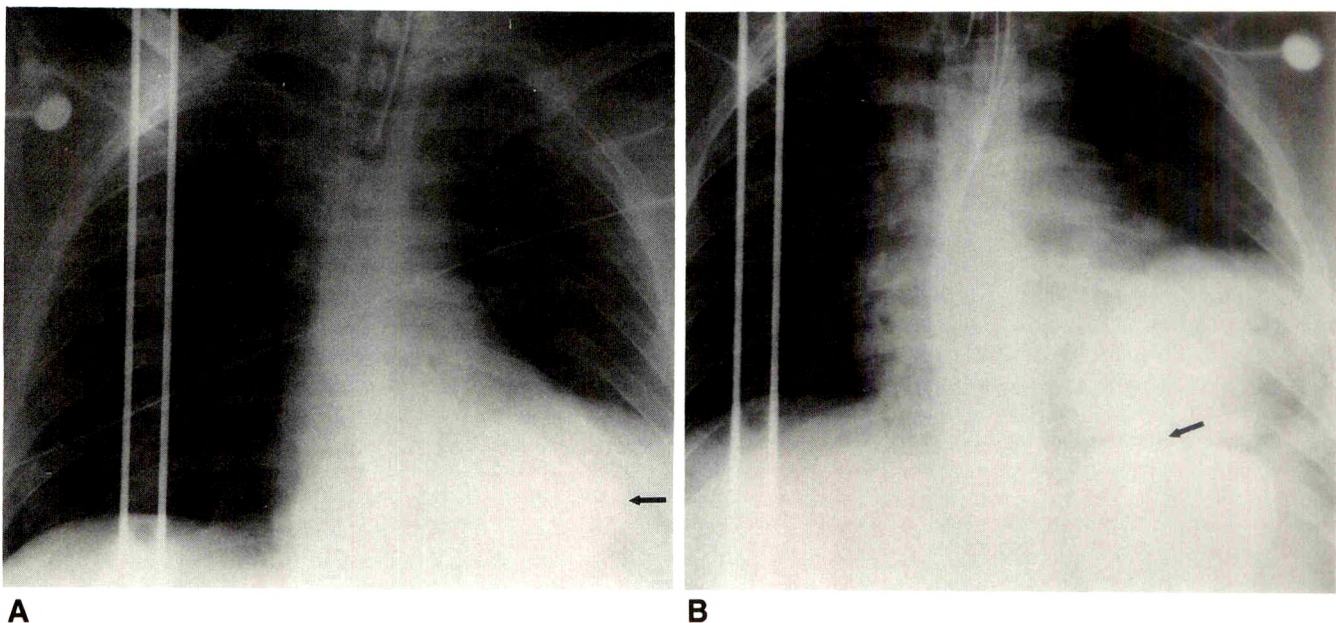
A, Chest radiograph reveals an apparently elevated left hemidiaphragm and a retrocardiac density suggestive of a fluid-filled gastric fundus (arrow). No mediastinal shift is present.
